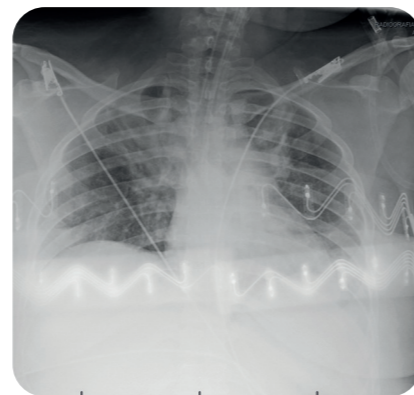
Follow-up chest X-ray on Day 2 showed significant improvement of alveolar infiltrates.
